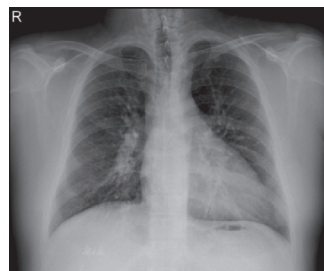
Chest X-ray taken one week later reveals no active infiltrative lesion in the lung parenchyma. Bilateral cardiophrenic and costophrenic sinuses are also clear.
